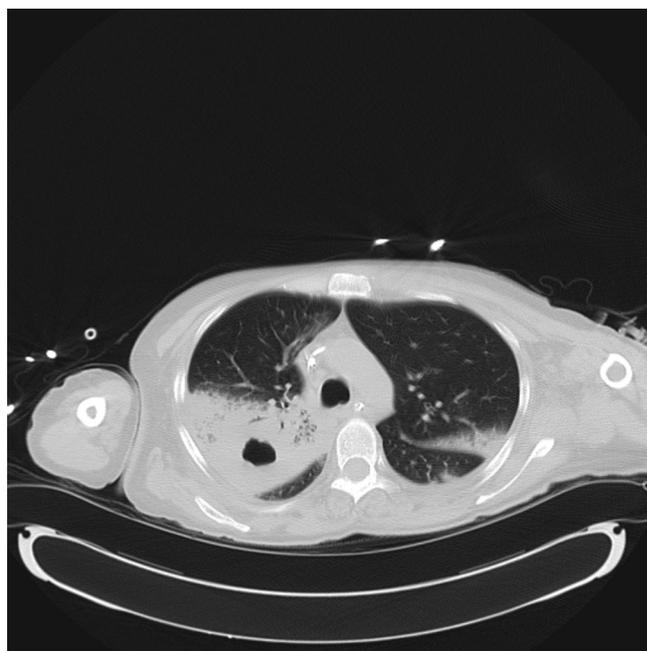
CT scan of the chest revealing consolidation with cavitary lesion in the right upper lobe.
